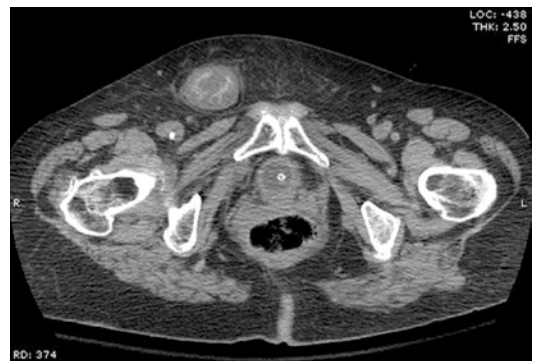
Computed tomography scan showing incarcerated right femoral hernia causing a bowel obstruction which lead to ischemic intestine, pneumatosis, and portal venous gas
